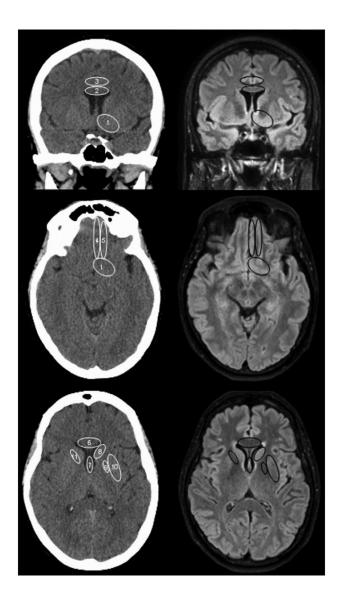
Proforma for identification of infarct location (multiplanar CT reconstructions, left and FLAIR axial and coronal images, right): (1) basal forebrain; (2) body of corpus callosum; (3) cingulate gyrus; (4) gyrus rectus; (5) medial olfactory gyrus; (6) genu of corpus callosum; (7) fornix; (8) caudate nucleus; (9) globus pallidus; (10) putamen; (11) anterior limb of internal capsule.
